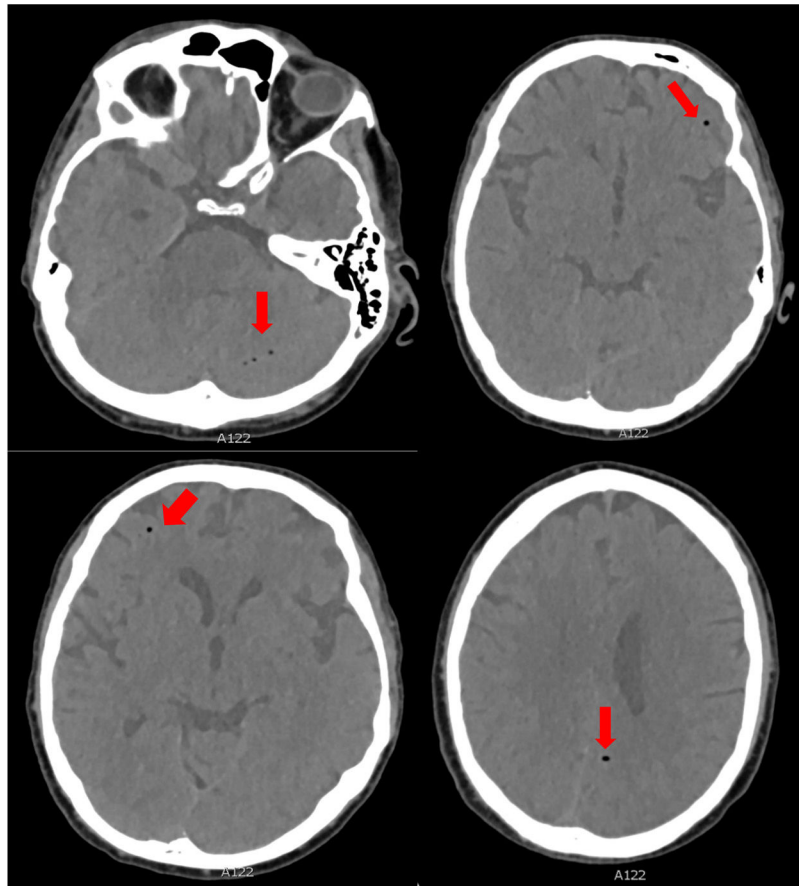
Head CT scan showing multiple air bubbles in both frontal and parietal lobes, the left temporal lobe, left cerebellar hemisphere, and both pterygopalatine fossae; these images are compatible with air embolism.
